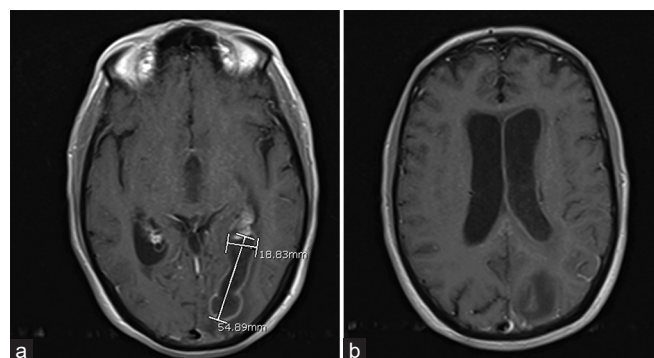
Magnetic resonance images (a and b) of the brain showing a ring-enhancing left occipital lesion with intraventricular enhancement consistent with intraventricular rupture of an intracranial abscess.
